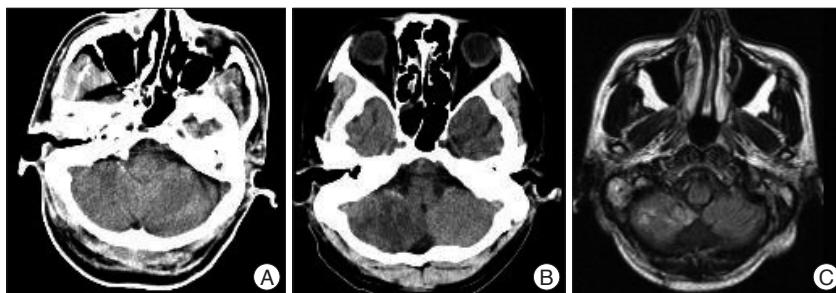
Postoperative radiological imaging studies. A : There is no evidence of cerebellar infarction immediately after the endovascular embolization. B : On postoperative day 3, brain computed tomographic scan shows low density in the right cerebellar hemisphere. C : On postoperative day 14, FLAIR magnetic resonance imaging view reveals infarction in the right cerebellar hemisphere.
